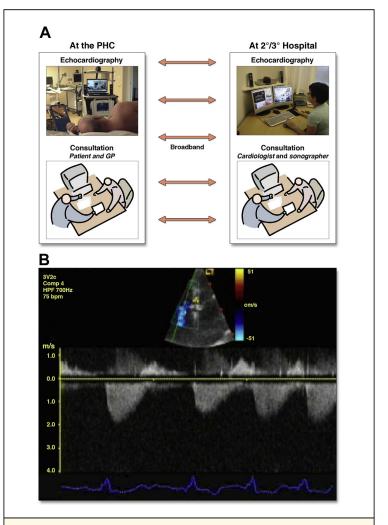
Cardiology Consultation From Distance and Tele-Ultrasound Imaging
